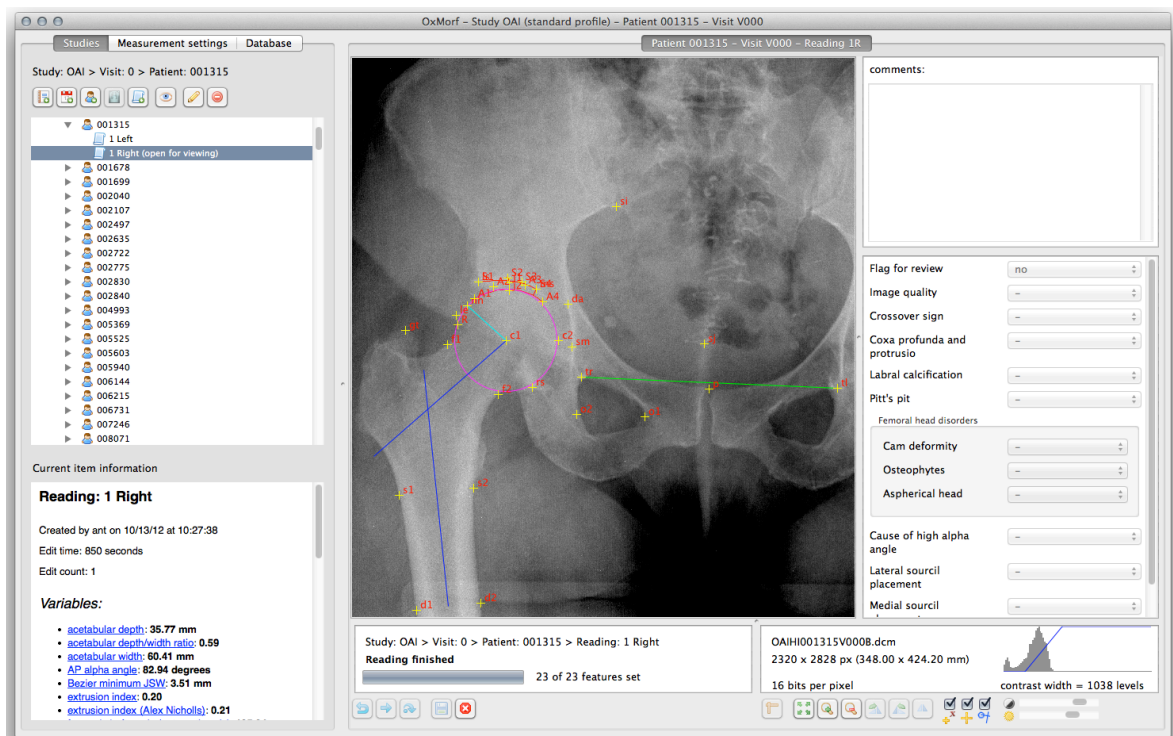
Hipmorf 3.0 - Marked up image of right hip from AP pelvis radiograph.
